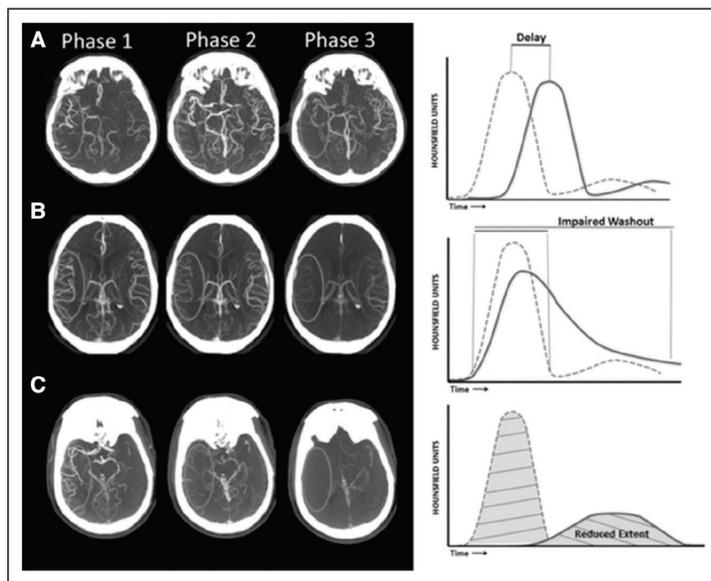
Admission multiphase computed tomographic angiography (mCTA) profiles for (A–C) 3 patients with L-middle cerebral artery-M1 occlusions, and corresponding hypothetical time–density curves for pial vessel enhancement. Contralateral hemisphere is outlined in blue for all patients and used as reference to ipsilateral enhancement. Delay was assessed by comparing the maxima appearance of CT contrast in the pial vessels in the ischemic region to maxima appearance within the same region within the normal hemisphere. Washout was assessed by comparing the pial vessel enhancement on the third phase mCTA compared with the second phase within each hemisphere. Extent was assessed by comparing the number of pial vessels in a particular ischemic region with the corresponding contralateral hemisphere in all phases of the mCTA acquisition.
